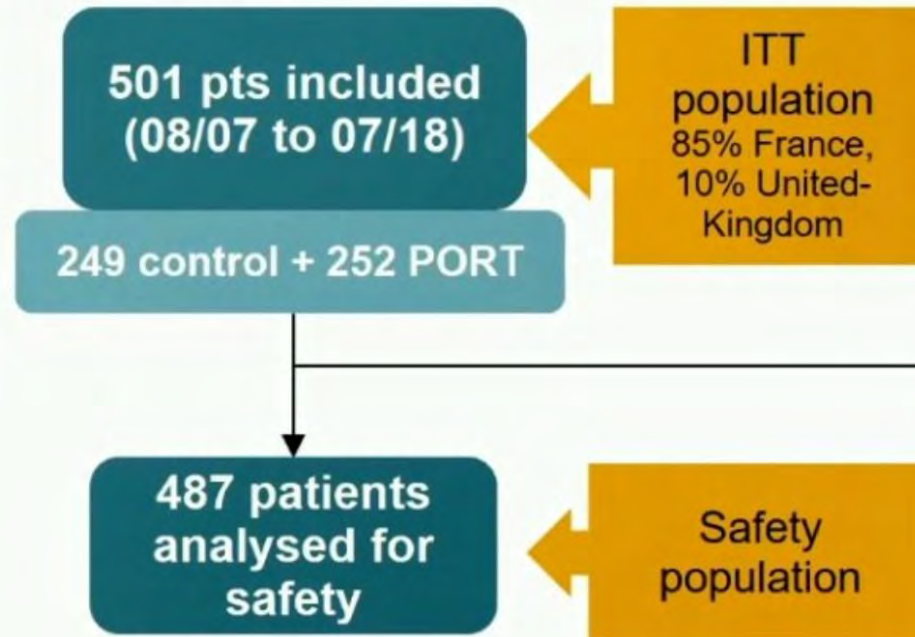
Lung adjuvant radiotherapy trial (ART) design. CT, computed tomography; DFS, disease-free survival; NSCLC: non-small cell lung cancer; PET, positron emission tomography; PORT, postoperative radiation therapy; post-op, postoperative; pre-op, preoperative; SCC, squamous cell carcinoma
